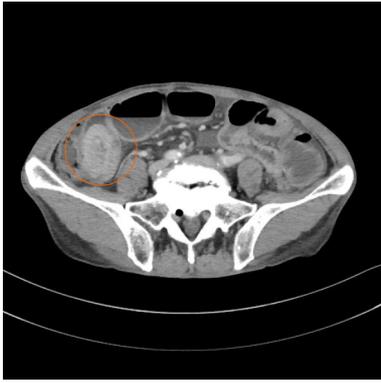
Abdominal contrast-enhanced computed tomography demonstrated an intussusception of the small intestine due to a well-defined, rounded, enhancing endoluminal mass (orange circle).
